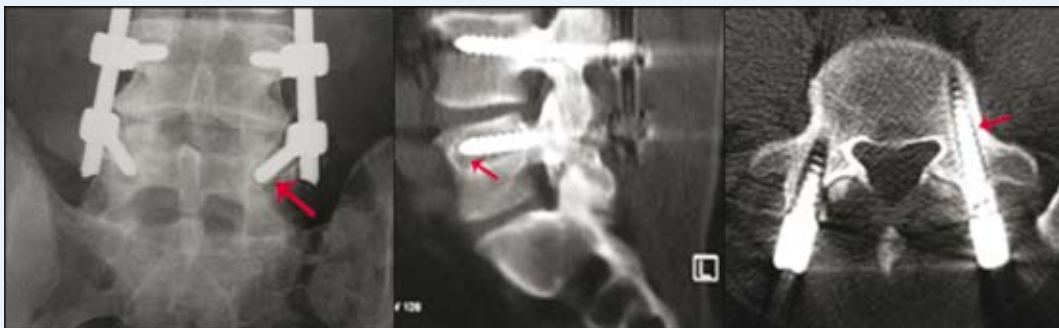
a) In direct radiograph, sagittal and axial CT radiolucent zones are seen around the screw that is depend on relaxation of screw.
